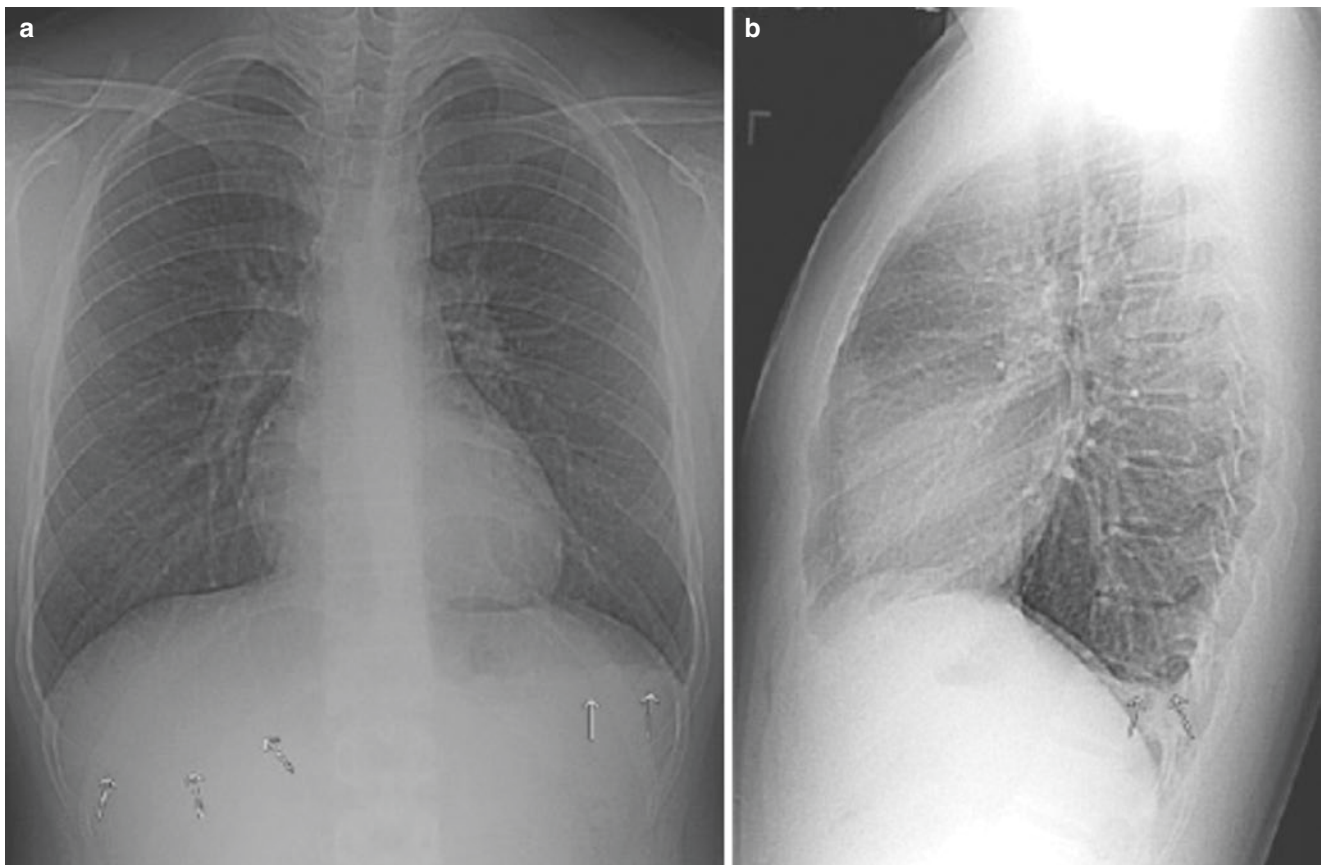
(a) Frontal chest radiograph: *Right arrows* indicate the normal posterior costophrenic margin. *Left arrows* point to the stomach air/fluid level. No clear effusion is noted. (b) Lateral chest radiograph: *Arrows* indicate a small left-sided pleural effusion, obscured by the gastric content on the PA image
